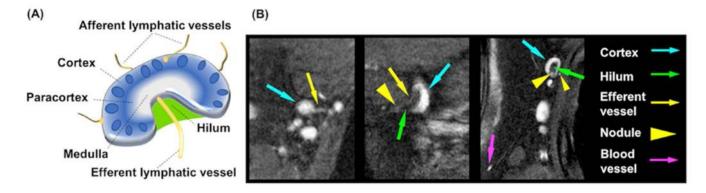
Axillary lymph node substructures visualized in vivo at 3.0T MRI.
